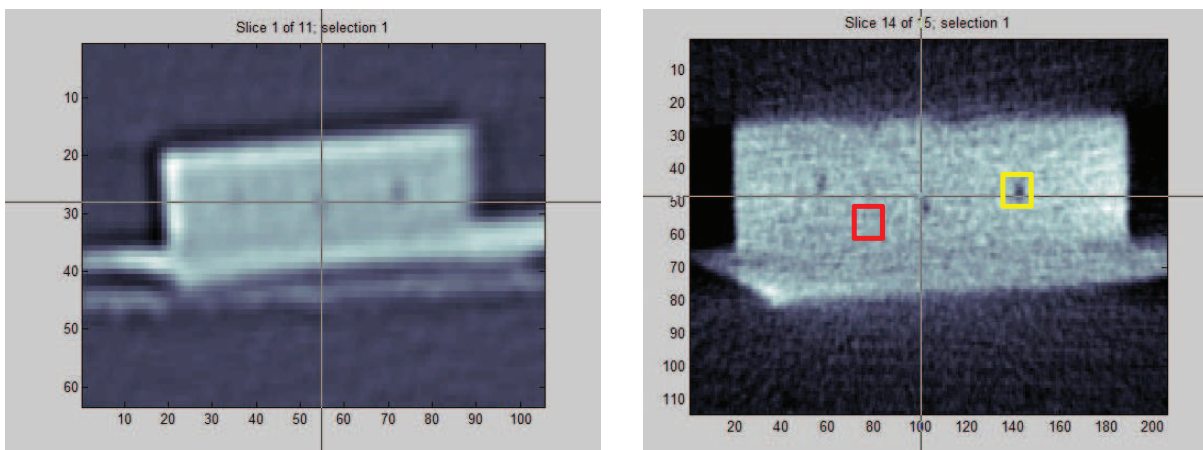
Manual selection of the ROI. A  $5 \times 5$  px matrix is then placed over the selected region. Left: Toshiba Aquilion MSCT; Right: Siemens HR Dyna CT. The yellow (slightly magnified) matrix indicates the selection of a hole. The red matrix contains only image noise.
